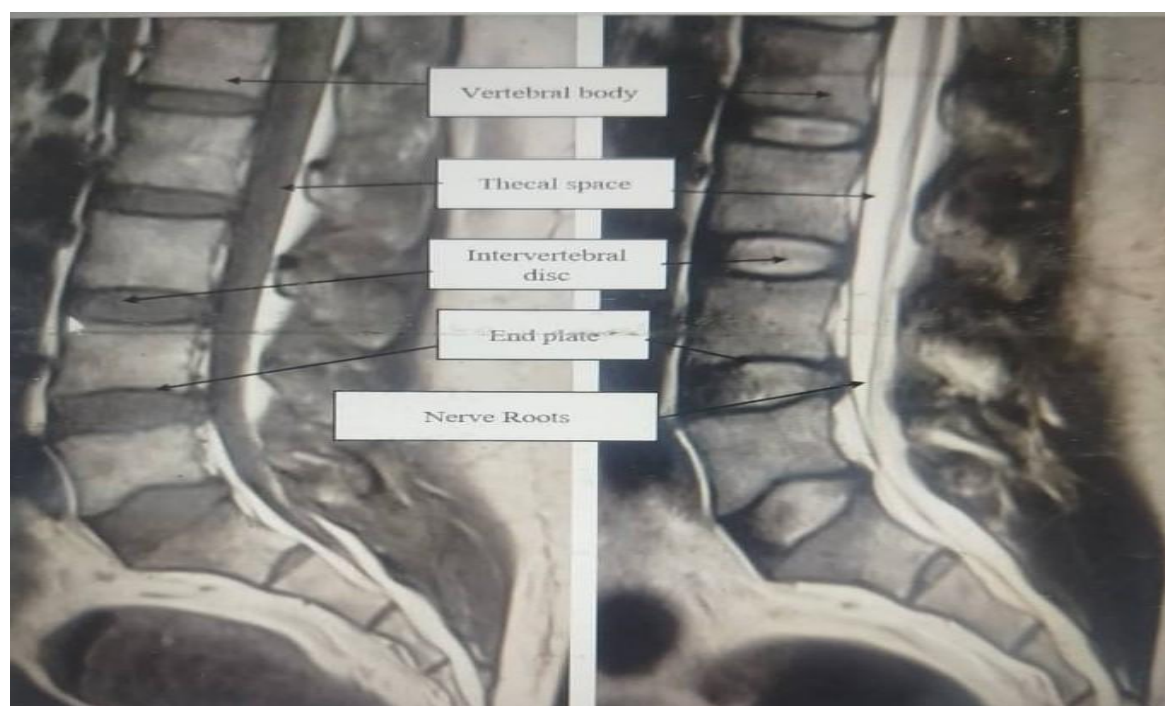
A T2- and T1- weighted magnetic resonance image showing the sagittal cross – sectional view of the lumbar spine.
